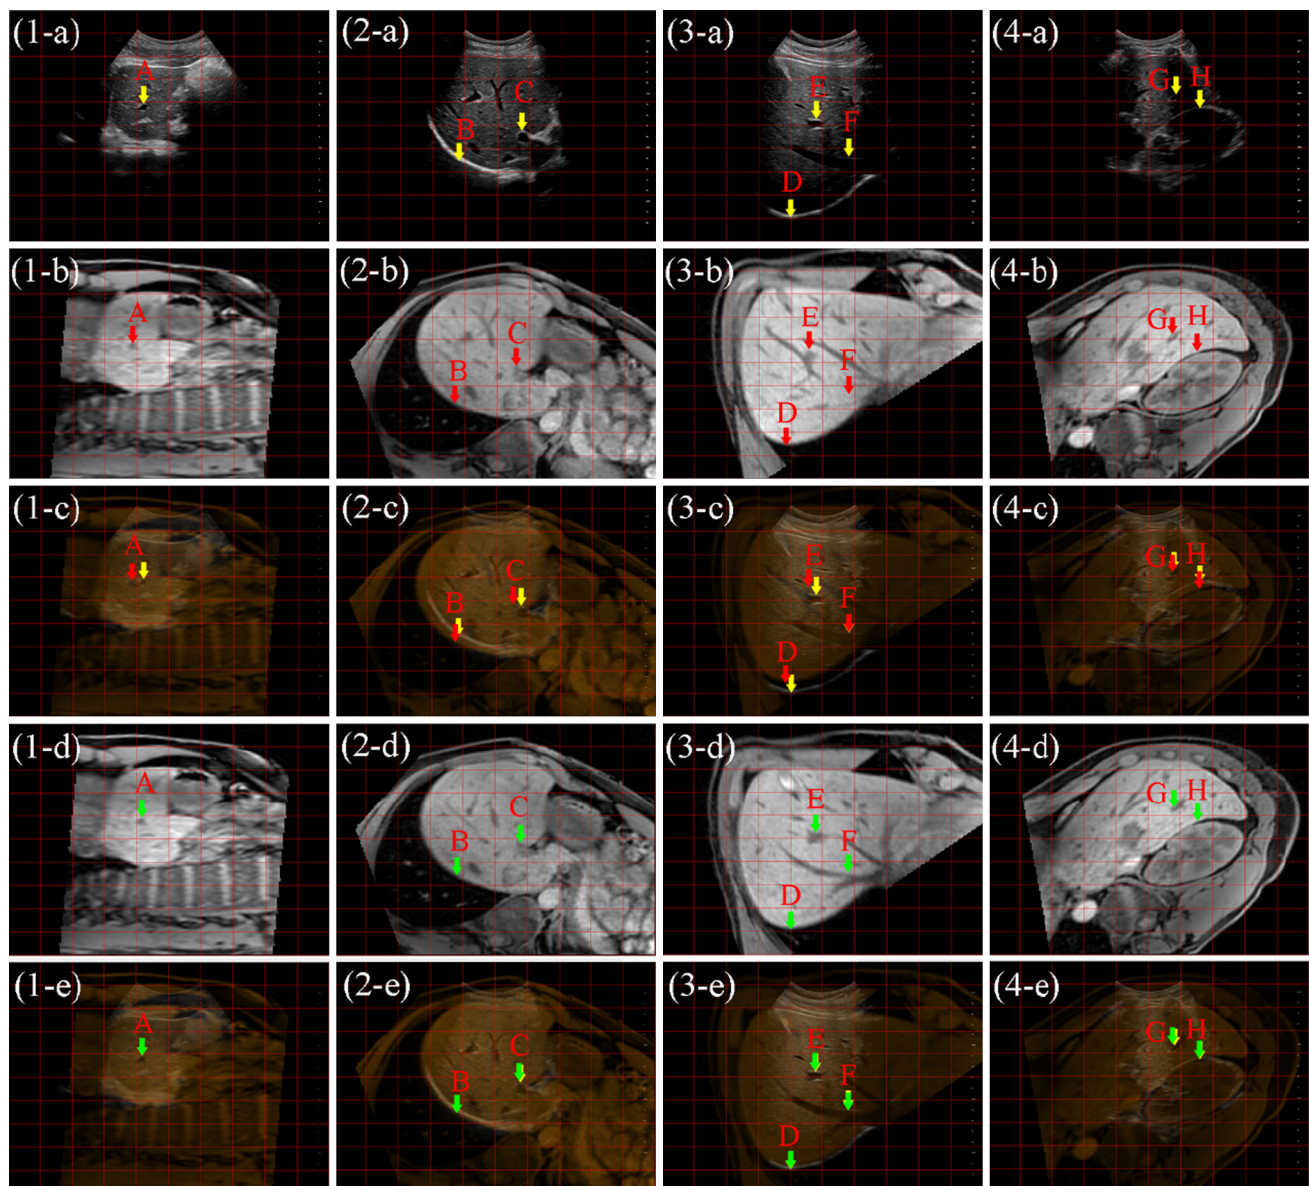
Compensation performance of the proposed liver motion prediction model. *Top row* is ultrasound slice, *second* and *third rows* are corresponding uncompensated MRI slice and its fusion display with ultrasound slice. The *fourth* and *fifth rows* are corresponding compensated MRI slice, and its fusion display. *Each column* is slices extracted from the sagittal slice of left liver (1), parallel intercostal (2), hepatic
